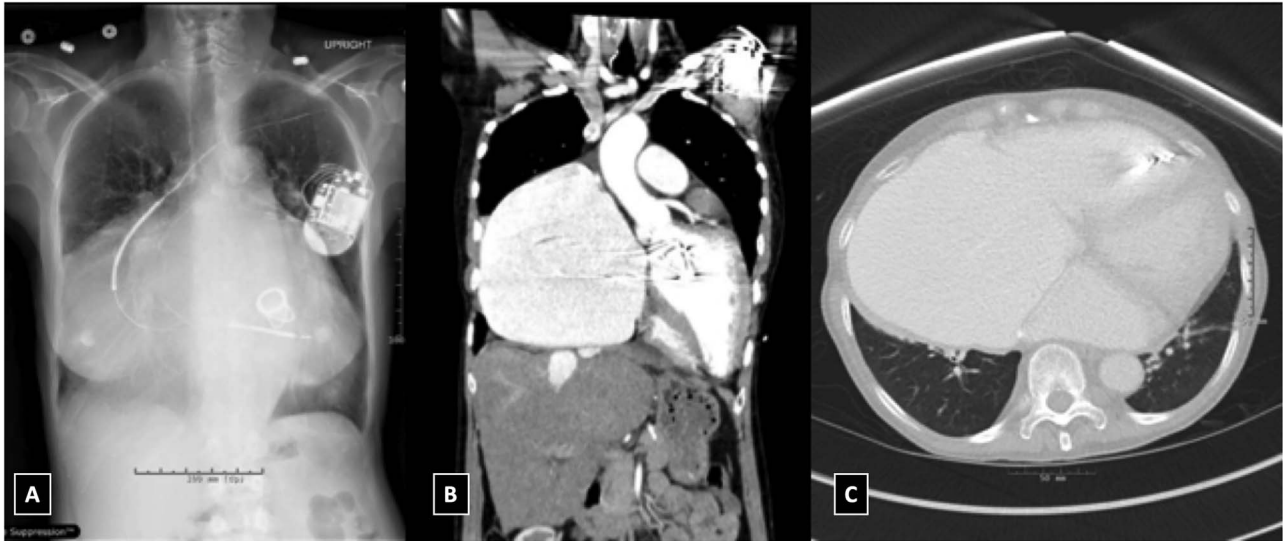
(A) Chest X-ray showing marked cardiomegaly with giant right ventricle filling most of the thoracic cage. (B) CT of the chest showing the heart and great vessels. (C) CT scan of the chest showing the four chambers of the heart.
